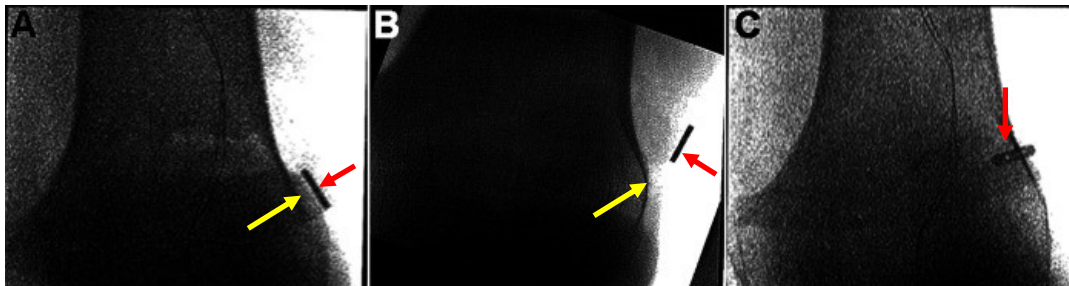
Intraoperative radiographs of the knee in ACL reconstruction. A – suture button (red arrow) appropriately seated on the lateral femoral cortex (yellow arrow). B- suture button (red arrow) misplaced away from the lateral cortex. C- suture button (red arrow) partially located in the femoral tunnel (intraosseous) (adapted from O’Brien et al., 2021).
